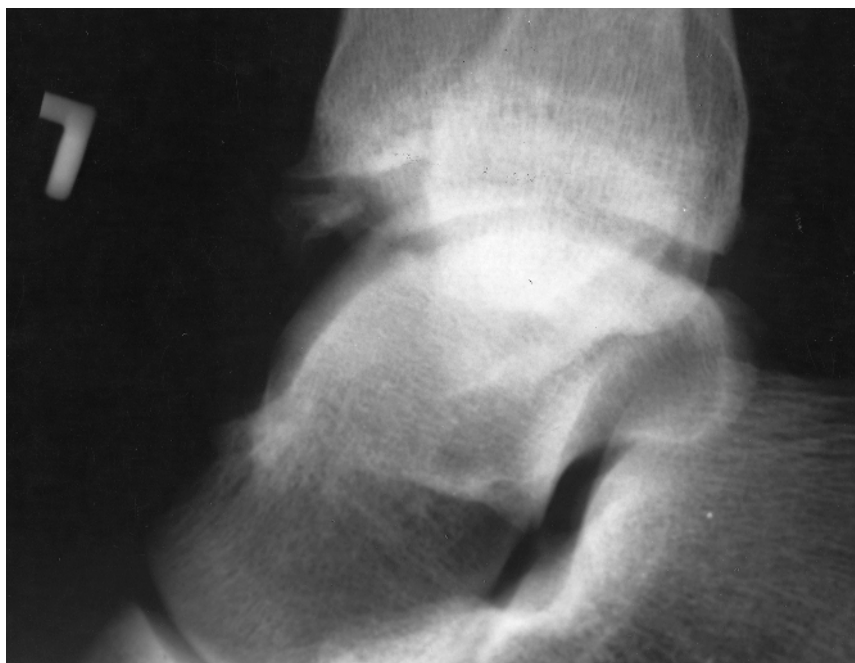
Lateral radiograph of the left ankle shows an anterior impingement (osteophyte) in a professional football kicker.
